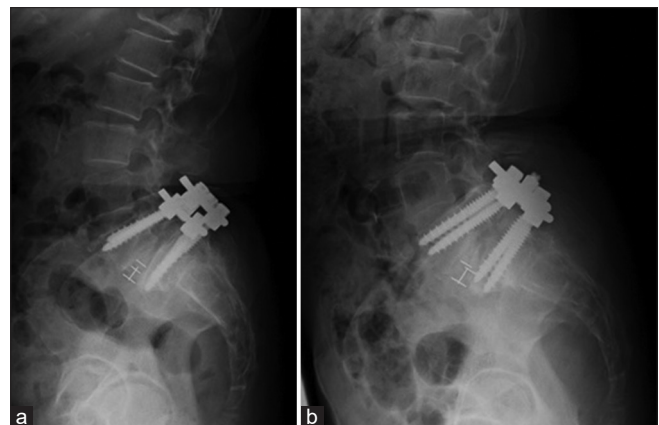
Lateral radiographs of the lumbar spine in the sitting (a) and supine positions (b) after lumbosacral fusion showing instability at the S1/S2 level.
